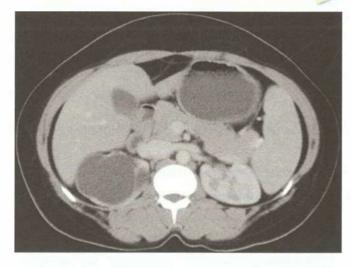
Right hydronephrosis—CT picture. Left kidney normal
